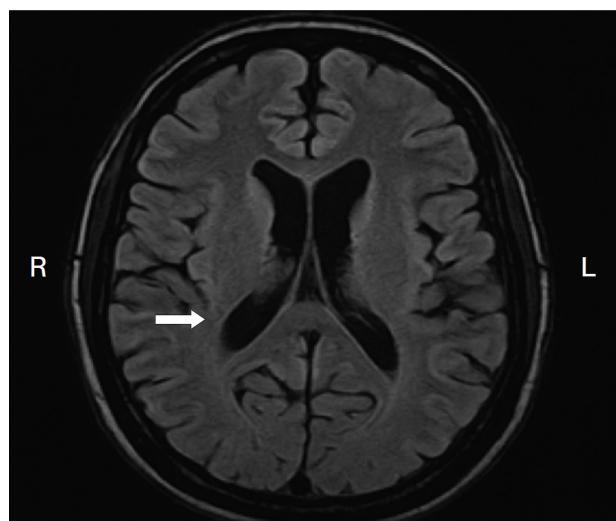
Axial T2-weighted FLAIR MRI showing bilateral caudate and putaminal atrophy with prominent lateral ventricles, consistent with neurodegenerative changes seen in Chorea-acanthocytosis
